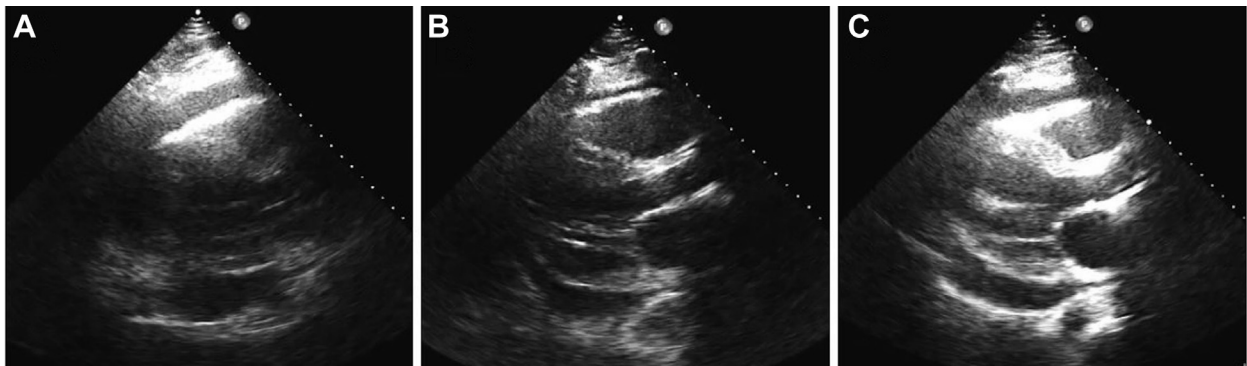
Two-dimensional TTE, parasternal long-axis view, early diastolic phase performed at the time of presentation, demonstrating the initial circumferential pericardial effusion (A), a smaller residual pericardial effusion soon after pericardiocentesis (B), and then rapid reaccumulation of the large pericardial effusion within minutes (C).
